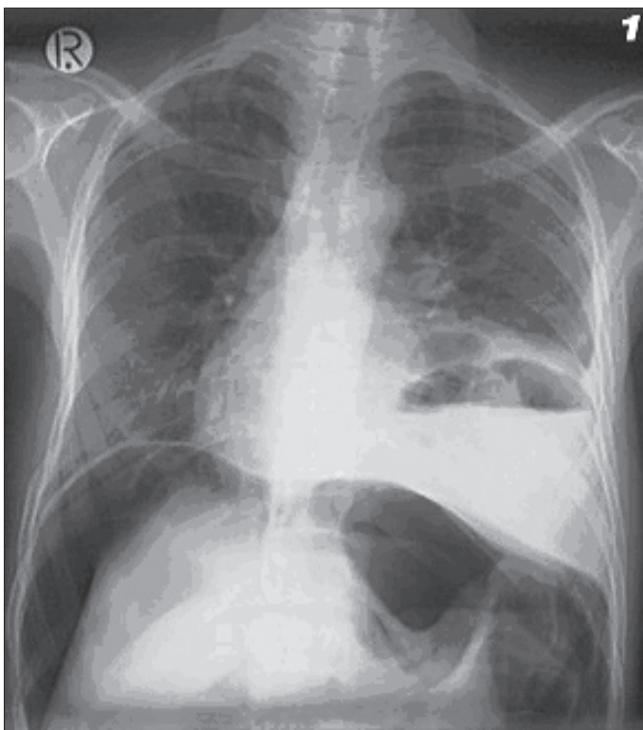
Anteroposterior chest radiograph, showing cystic lucencies above the left hemidiaphragm and sub-diaphragmatic free air on the right.
